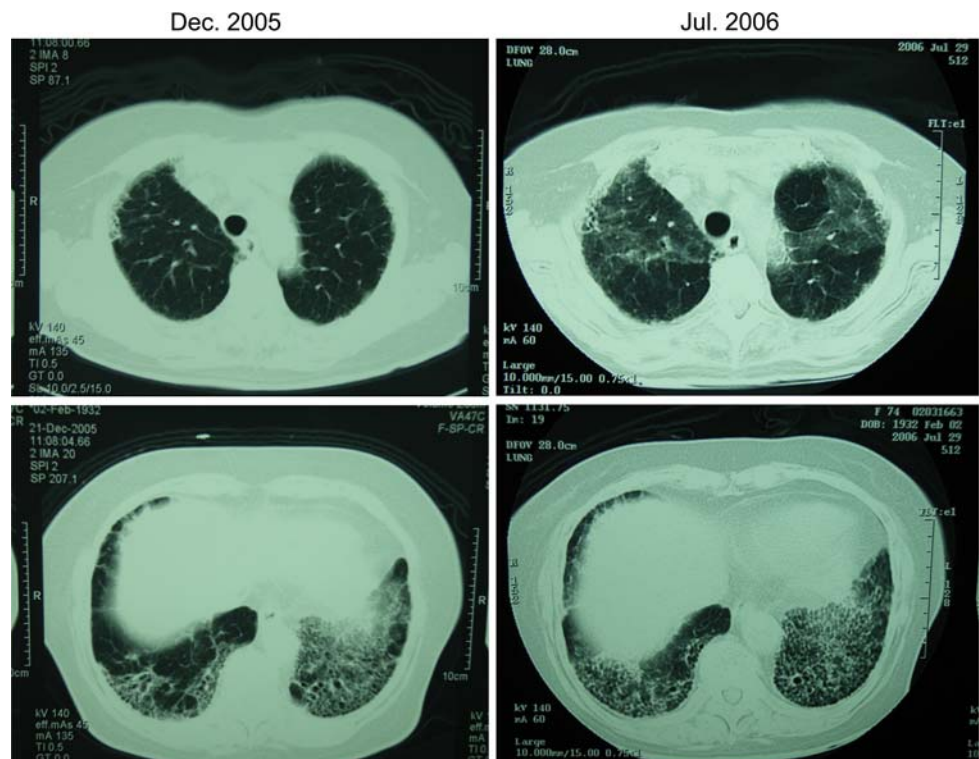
Left-sided chest radiograph showing an interstitial shadow on the lower lungs (Jan. 2006). Right-sided chest radiograph showing ground-glass opacity on the upper parts of both lungs and an interstitial shadow on the lower lungs (July 2006)
